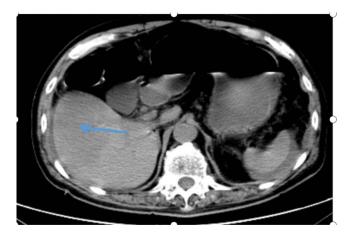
Plain scan shows multiple irregular low-density shadows of different sizes in the liver. The larger ones are located under the right lobe capsule with clear boundaries. The blue arrow points to the liver infarction lesion observed on CT plain scan.
